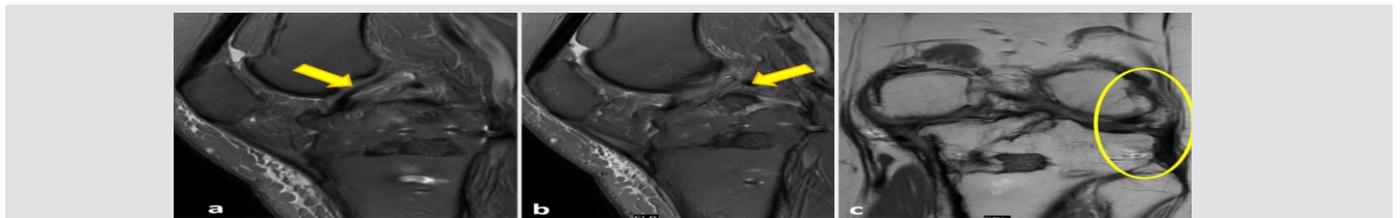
MRI Images of the knee. In proton-density fat saturated sequence, sagittal sections showing (a) an elongated anterior cruciate ligament (yellow arrow) and (b) absent posterior cruciate ligament. T2 weight coronal section showing disruption of the posterolateral complex (yellow oval).
